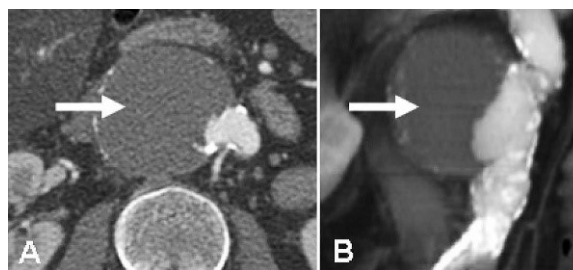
Figure ♦ Computed tomographic angiography showing an infrarenal penetrating aortic ulcer. (A) Axial view with extraluminal contrast (arrow). (B) Multiplanar reformation (coronal view) showing typical calcifications of the abdominal aorta and the PAU wall, with the contrasted lumen typically located off center, contrary to abdominal aortic aneurysms.
